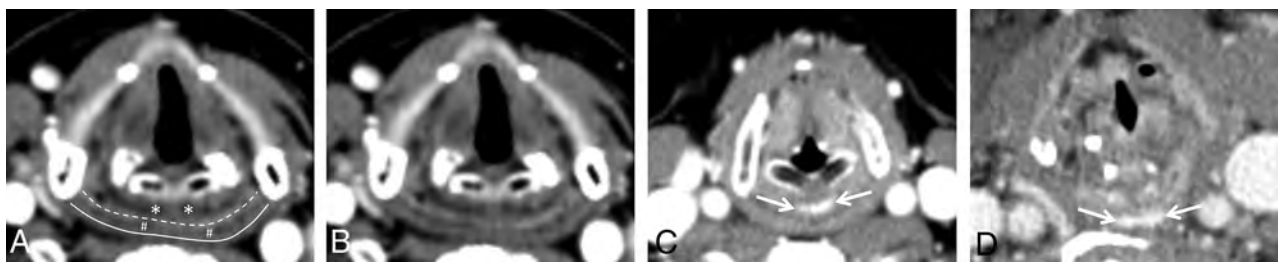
Labeled (A) and unlabeled (B) axial neck CT images with contrast at the level of the cricoarytenoid joints in a patient without visible PLVP demonstrate the expected locations of the PCVP (asterisk, A) between the larynx anteriorly and the hypopharyngeal mucosa (dashed line, A) posteriorly, and the PPVP (pound sign, A) between the hypopharyngeal mucosa anteriorly and the inferior constrictor musculature (solid line, A) posteriorly. Axial neck CT images with contrast in 2 additional patients (C and D) demonstrate visible PCVP (arrows, C) and visible PPVP (arrows, D).
